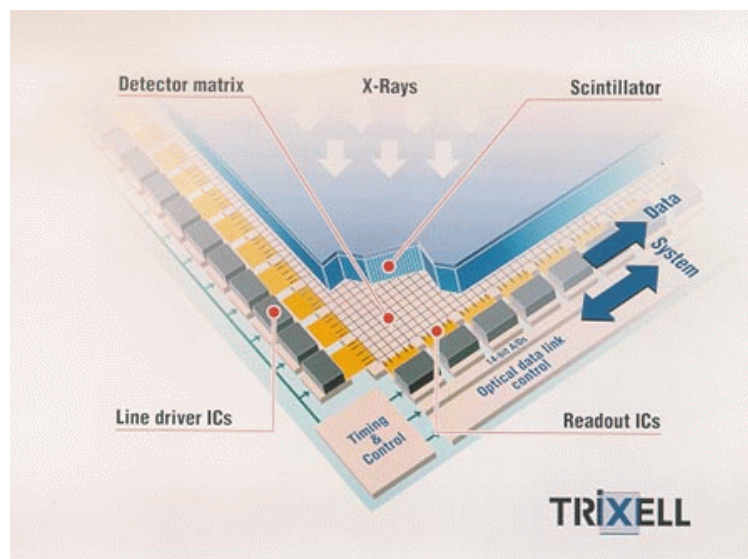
Technology of the Pixium 4600 X-ray detector
